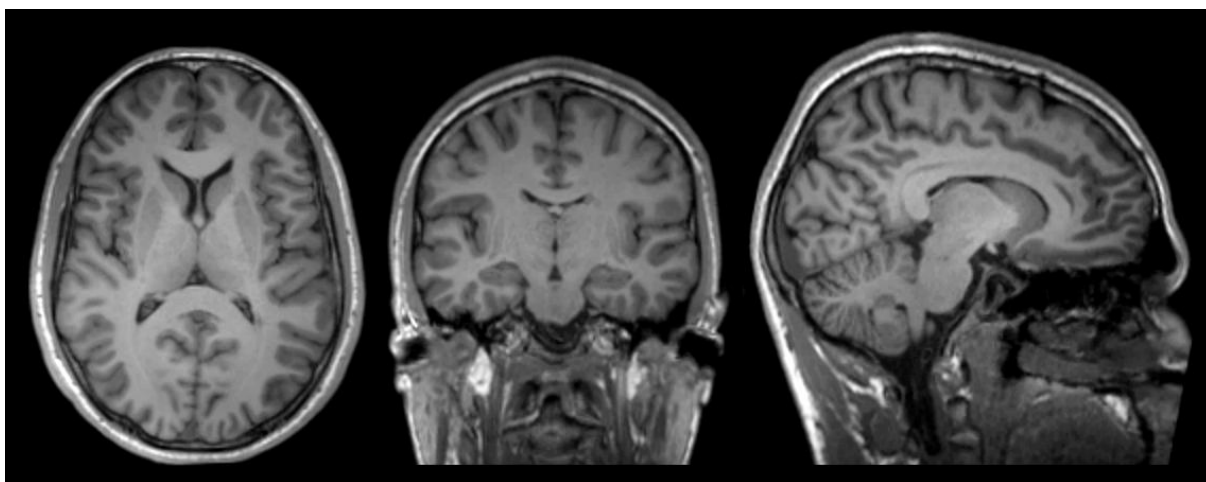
Example of different cross sections of MPRAGE images with a 32 channel head coil at a 3T MRI unit.
